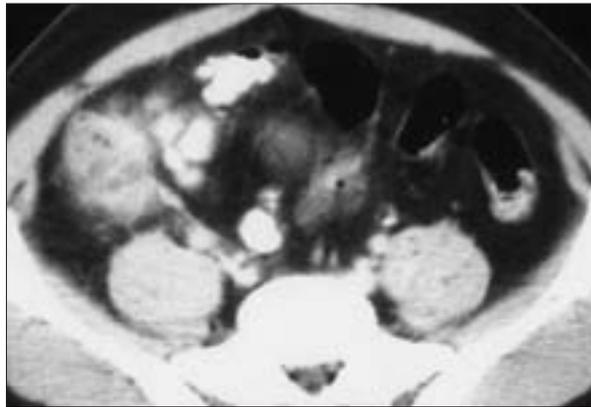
On axial CT image of an acute appendicitis case, periappendiceal soft tissue mass, with a variable degree of enhancement representing a phlegmon is evident.
